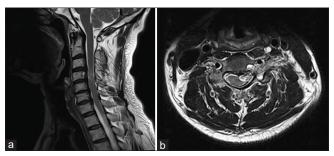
(a) Postembolization Magnetic resonance imaging showing complete collapse of the dilated flow void (b) Postembolization axial magnetic resonance imaging showing complete collapse of the dilated flow void with axial section showing glue cast in the flow voids
